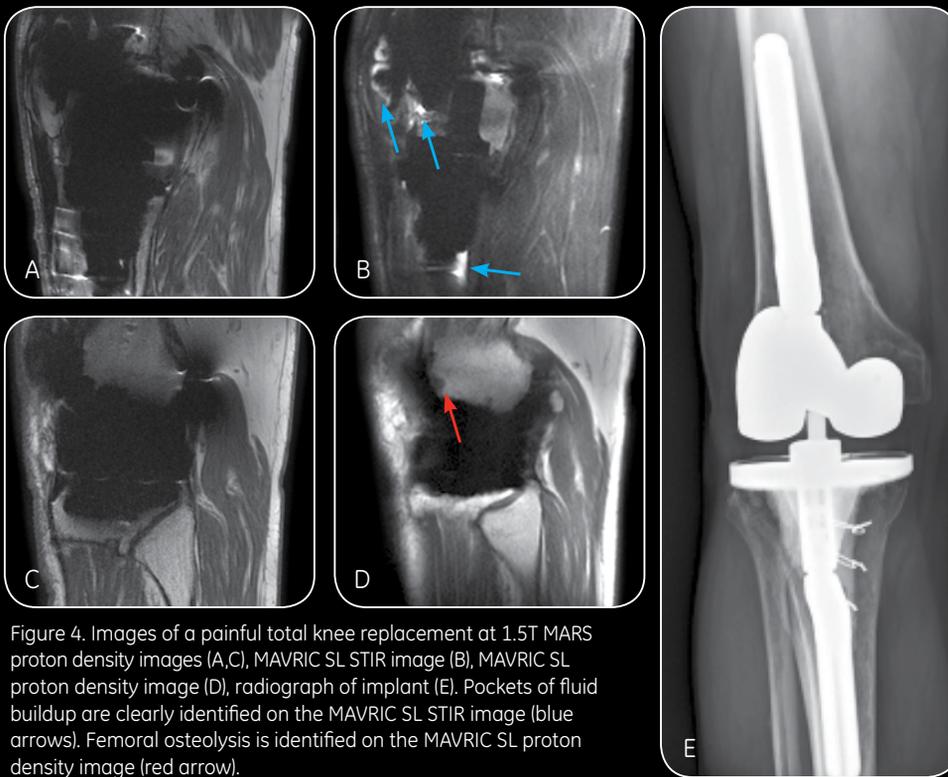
Images of a painful total knee replacement at 1.5T MARS proton density images (A,C), MAVRIC SL STIR image (B), MAVRIC SL proton density image (D), radiograph of implant (E). Pockets of fluid buildup are clearly identified on the MAVRIC SL STIR image (blue arrows). Femoral osteolysis is identified on the MAVRIC SL proton density image (red arrow).
